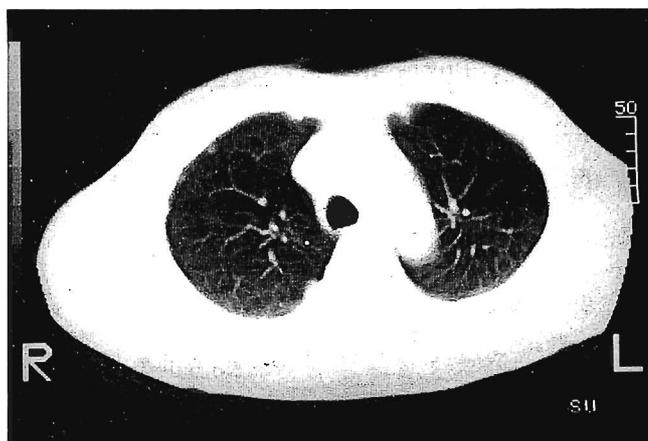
Chest CT scan showing two pleural nodules without effusion (primary tumor is not seen at this level). It is difficult to make an accurate diagnosis whether it is pleural dissemination or not.
